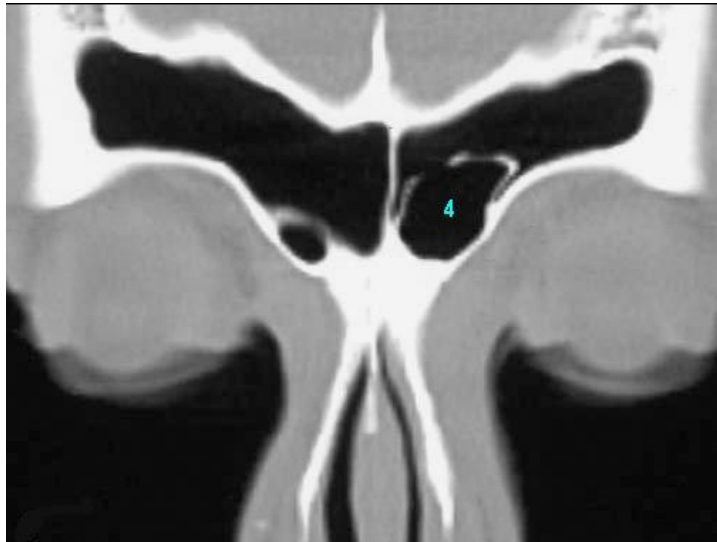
Coronal CT showing type IV frontal cell
